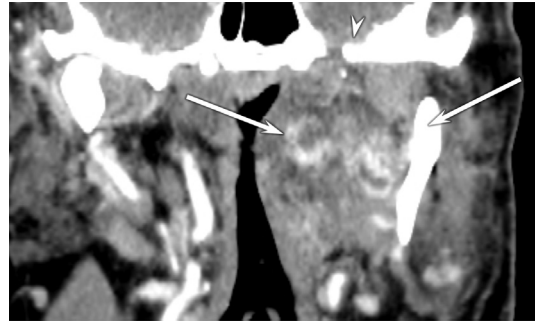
Coronal CT reformat in a patient with recurrent pleomorphic adenoma demonstrates multispacial recurrent tumor (*arrows*), which involves the parotid and masticator spaces, just caudal to the level of foramen ovale (*arrowhead*) in a patient with Frey syndrome.
